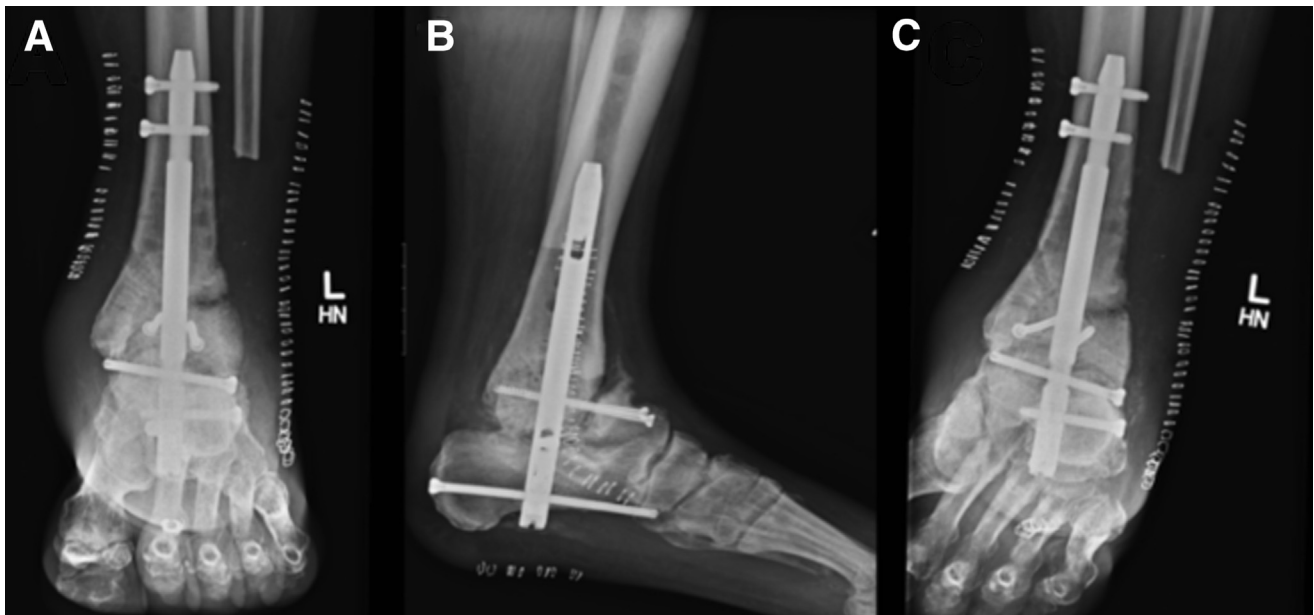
(A, B, C) Postoperative anteroposterior, lateral, and mortise non-weight-bearing radiographic views of the left ankle following a tibiototalcalcaneal arthrodesis with femoral head allograft and intramedullary nail.
